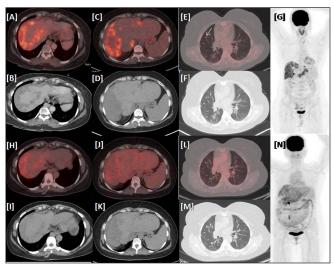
Baseline 18-F-FDG PET-CT revealed ill-defined hypodense lesion with heterogeneously increased FDG uptake in segment V–VIII and discrete hypodense lesions with increased FDG uptake in segment I, II, and IV of liver with multiple subcentimeter sized perigastric, paraortic, aortocaval lymph nodes, and bilateral pleural and parenchymal-based nodules in the bilateral lung fields (A)–(G). Subsequent 18-F-FDG PET-CT following Sorafenub therapy after 6 months revealed decrease in the size and uptake of the liver, lymph nodes, and lung lesions representing partial response to therapy (H)–(N).
